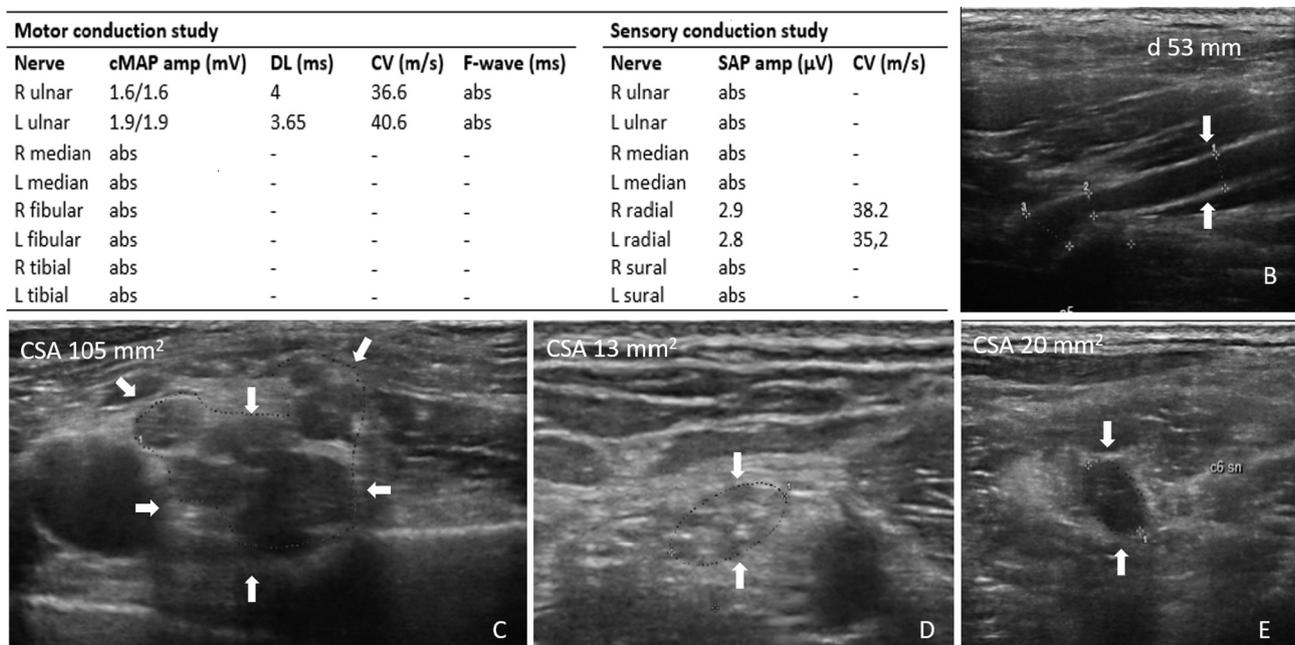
(A) Nerve conduction study. DL: distal latency, CV: conduction velocity, R: right, L: left, abs: absent, amp: amplitude, cMAP: compound muscle action potential (expressed as wrist amplitude/under elbow amplitude), SAP: sensory action potential. (B–E) High resolution nerve ultrasonography. Diffuse enlargement of cervical roots, brachial plexus and median nerve at the arm bilaterally. (B) Left C5 root (long axis). (C) Left brachial plexus at supraclavicular space (short axis). (D) Right median nerve at arm (short axis). (E) Right C6 root (short axis). CSA: cross sectional area. d: diameter.
